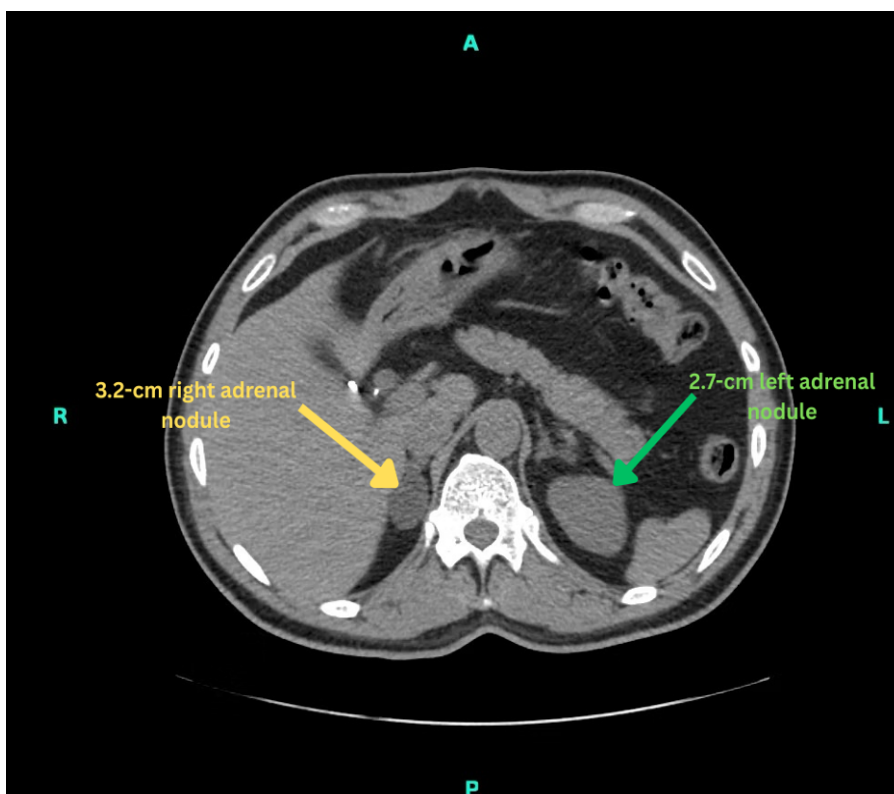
Non-contrast CT of the abdomen revealing bilateral adrenal adenomas. Bilateral adrenal lipid-rich adenomas. Axial non-contrast computed tomography images demonstrate a 3.2-cm right adrenal nodule (yellow arrow) and a 2.7-cm left adrenal nodule (green arrow). Both lesions are well circumscribed and homogeneous, with imaging characteristics consistent with lipid-rich adrenal adenomas. No evidence of local invasion or regional lymphadenopathy is present.
